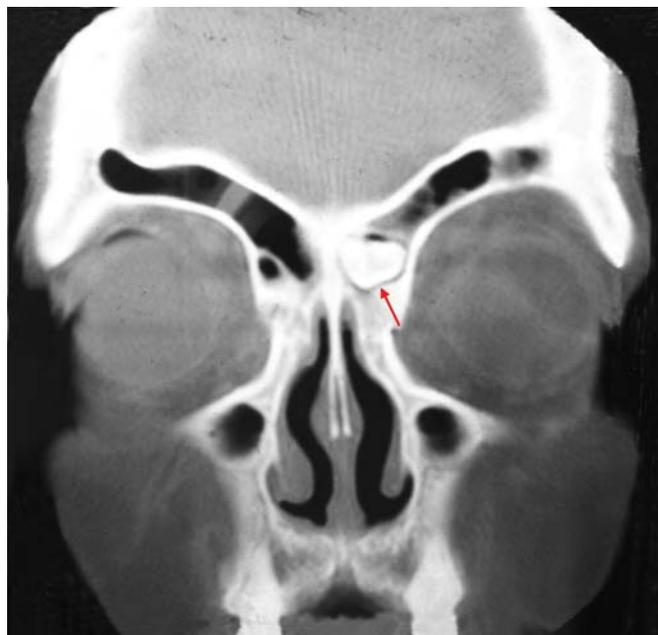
CT paranasal sinuses (coronal view) revealed mucosal thickening in frontal sinus
